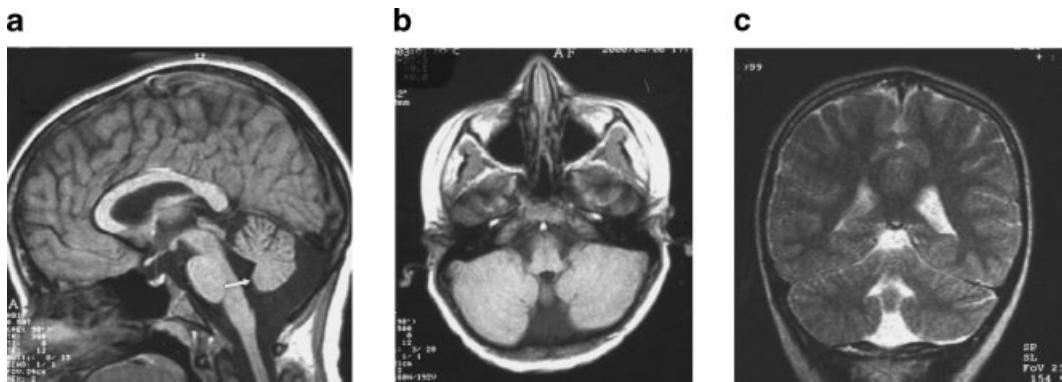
Brain MRI from patient 2: Sagittal T1-weighted (a), axial T1-weighted (b), and coronal T2-weighted (c) images showing a marked dilatation of the liquor spaces delimiting posterior and inferior vermis, with a large communication between fourth ventricle and basal cistern because of nodular lobule hypoplasia (arrow). Pyramidal lobule and uvula are also hypoplastic.
